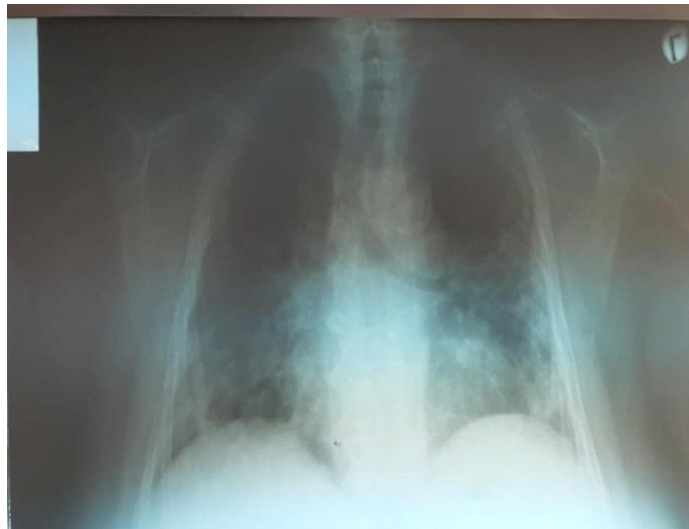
Chest x-ray on the day 14
